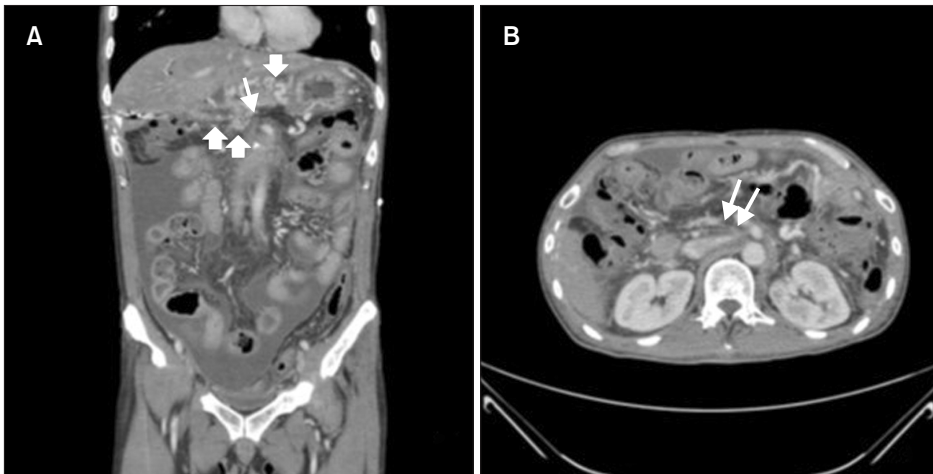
Preoperative computed tomography scan revealed the obliteration of portal vein (thin arrows in coronal view [A] and axial view [B]). Gastric and hepaticojejunostomy varices (thick arrows in A) due to portal hypertension were observed.
